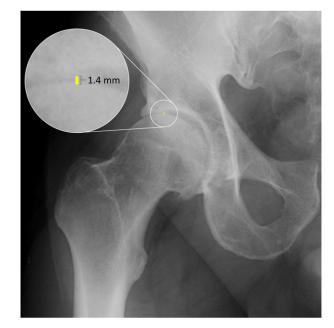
Joint space width measured from AP pelvis radiograph with neutral tilt and rotation with coned-in view to focus on superolateral weight-bearing region of the joint.
